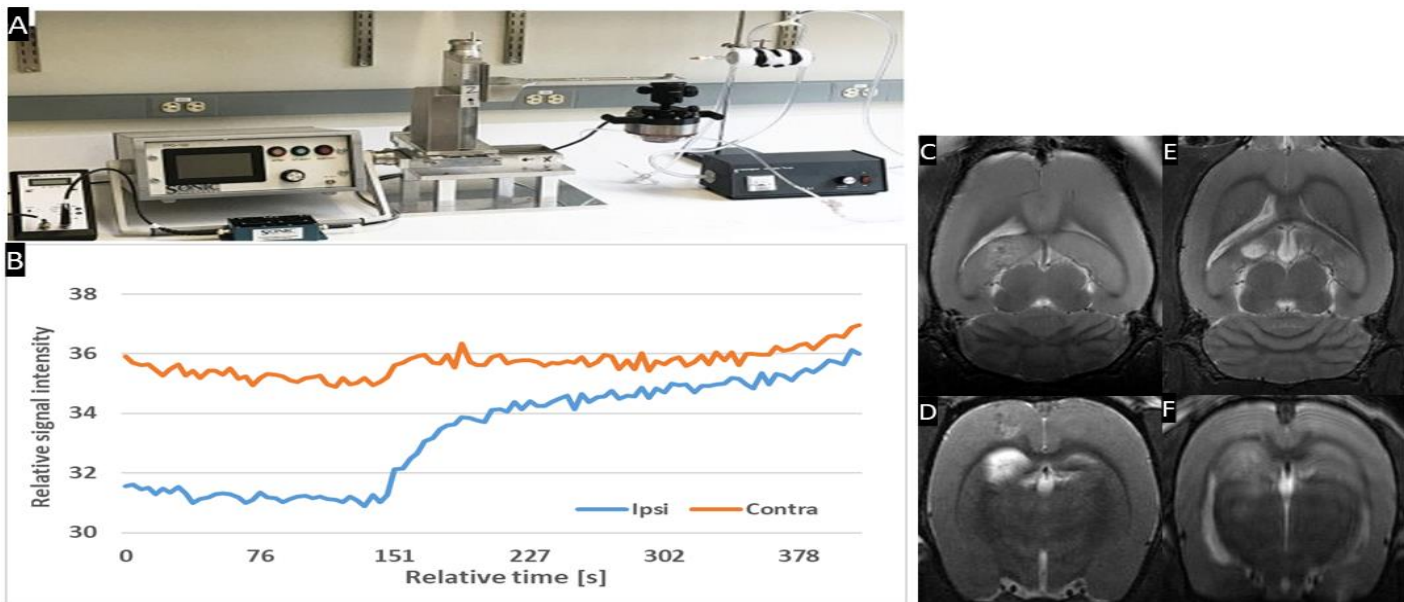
Overview of the FUS system, based on Biomed Eng Online. 2019; 18: 36 (A); the contrast enhancement dynamics acquired from DCE MRI at sonication (“ipsi”) area and corresponding contralateral area; T2-weighted images taken after the sonication (C,D) as well as 9 days post-FUS (E,F).
